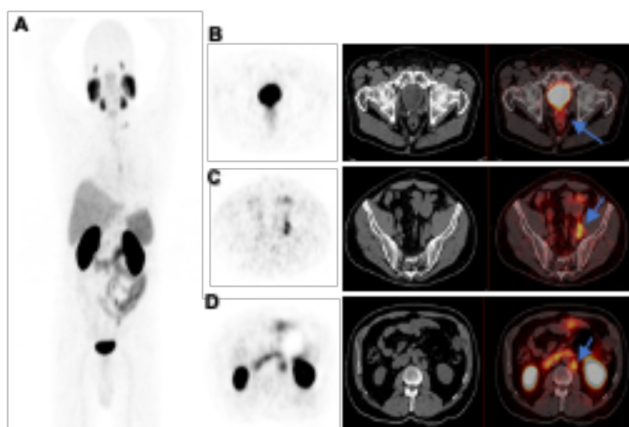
⁶⁸Ga-PSMA 11 PET/CT restaging in 62-years-old patient with biochemically recurrent prostate cancer and rising level of prostate-specific antigen: PET maximum intensity projection (A), axial PET/CT post-radical prostatectomy state, low expression of PSMA in the rectovesical septum (SUV_{max}: 3.2, score 1) (B), lymph nodes with moderate expression of PSMA, score 2, in the left internal iliac chain (SUV_{max}: 6) and in the left interiliac region (SUV_{max}: 5.9, score 2) (C), in the left common iliac chain (SUV_{max}: 8.2), para-aortic up to approximately 20 mm in greatest diameter (SUV_{max}: 7.3), interaortocavus (SUV_{max}: 5.3) (D)
